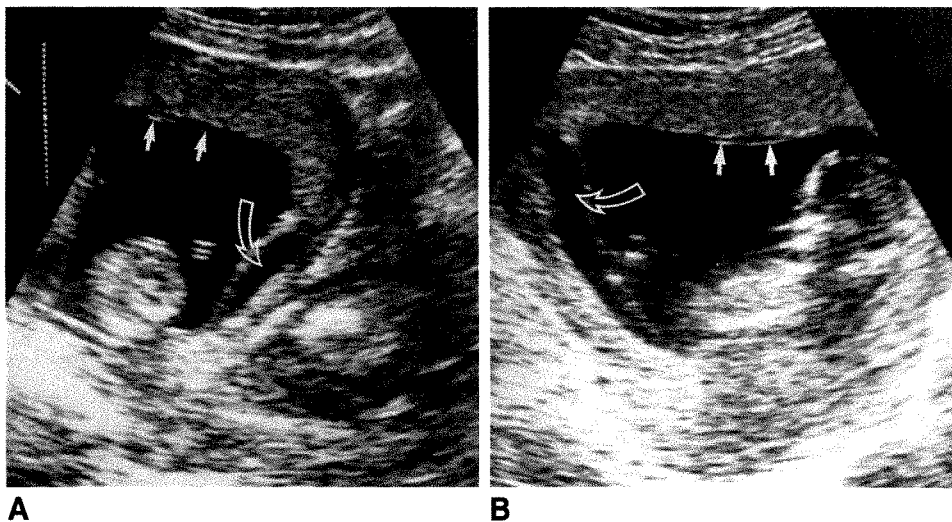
A and B, Transverse (A) and longitudinal (B) sonograms at 13 menstrual weeks show membranes and border of placenta to be lifted from uterine wall by subchorionic hemorrhage (open arrows) (estimated volume, 10 ml). Note amniotic membrane over fetal surface of placenta (solid arrows). Pregnancy was successful.
